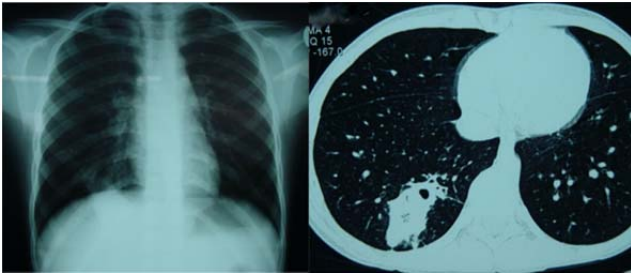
Chest X-ray and CT scan of patient
